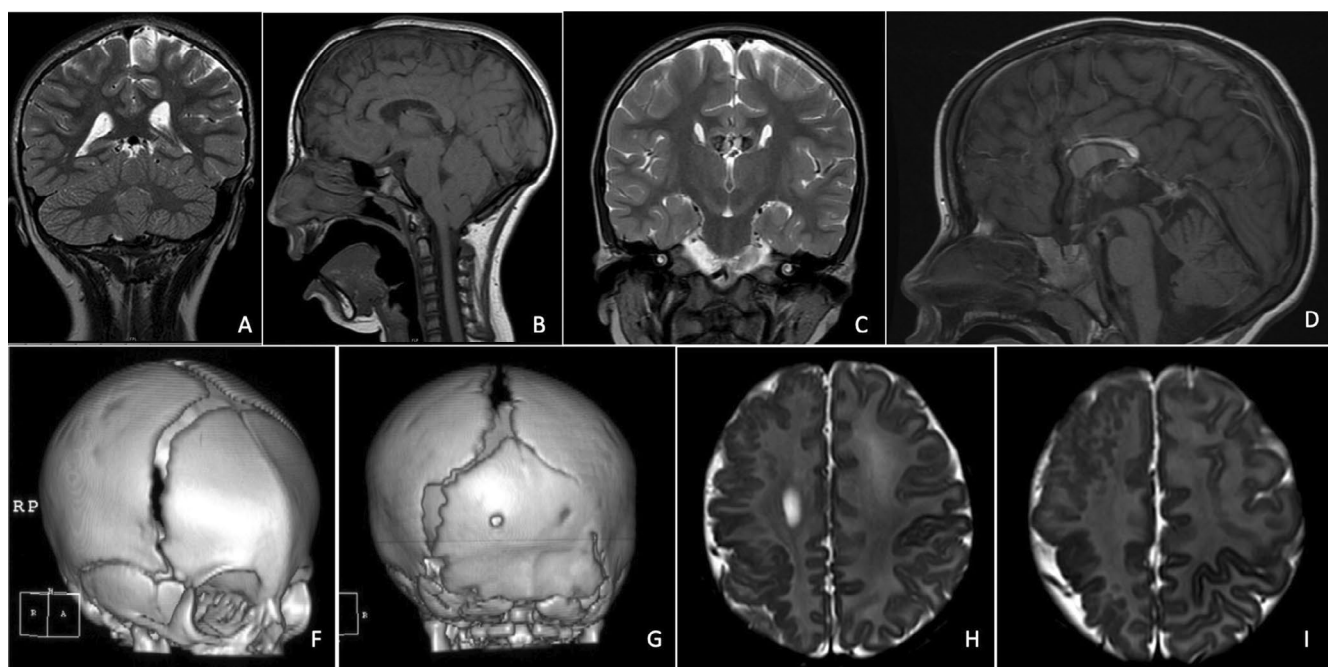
Selected radiological features. (A, B) Brain MRI from participant #11 performed at 5 years of age shows asymmetric cerebral and cerebellar hemispheres (A) and Arnold-Chiari malformation (B). (C, D) Brain MRI from participant #4 shows partial agenesis of the corpus callosum associated with lipoma (performed at 5 years of age). (F, G) Computed tomography scan of the skull performed at 1 month and 6 days of age shows precocious fusion of the metopic (F) and right lambdoid (G) sutures in participant #11. (H, I) Brain MRI from participant #6 (10 days old) shows a wide area of polymicrogyria, mostly in the anterior region of the right side.
